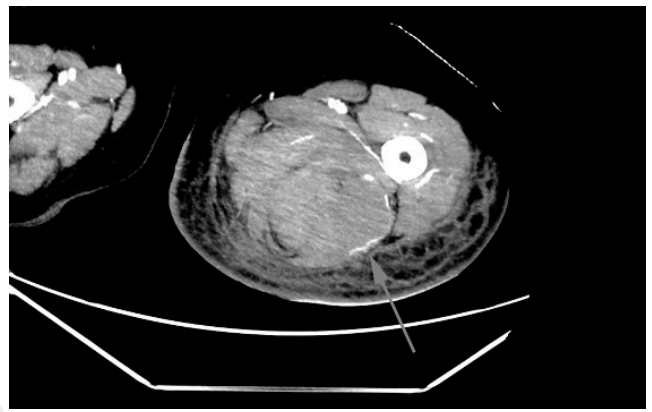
Maximum intensity projection MPR of angio-CT delayed phase showing extravasated contrast within the haematoma – active bleeding (arrow)
